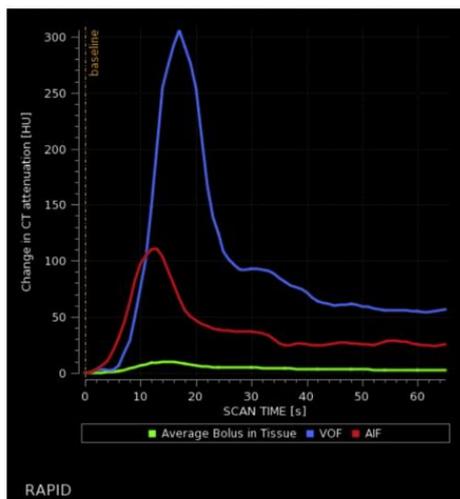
Arterial inflow function (AIF) and venous outflow function (VOF) tracings of a computed tomography (CT) perfusion scan, demonstrating a rise in AIF attenuation first, followed by VOF attenuation, ending with the VOF function reaching a plateau.
